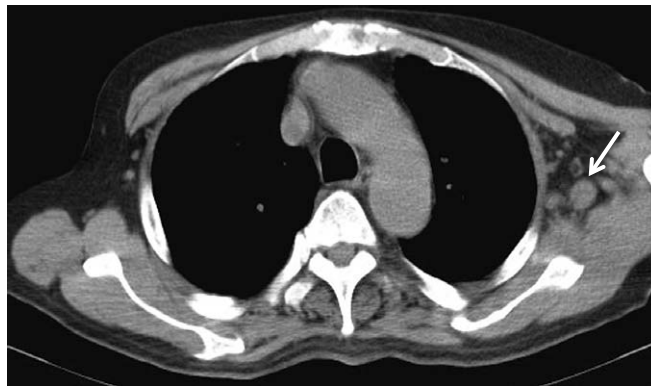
Chest computed tomography (CT) shows left axillary lymphadenopathy is indicated by the arrow.
